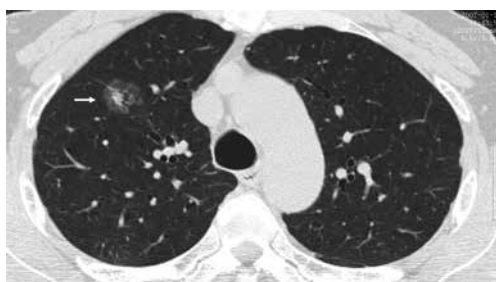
CT shows a case of minimally invasive adenocarcinoma, with a total size of 17 mm and solid component size of 7 mm.
